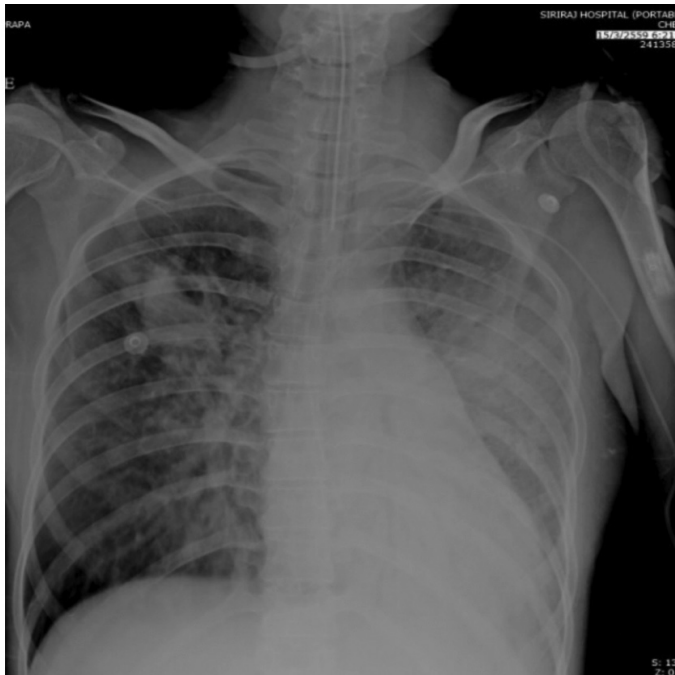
Chest radiography reveals increase infiltration in the left upper lung field and a newly detected consolidation in the right middle lung field.
